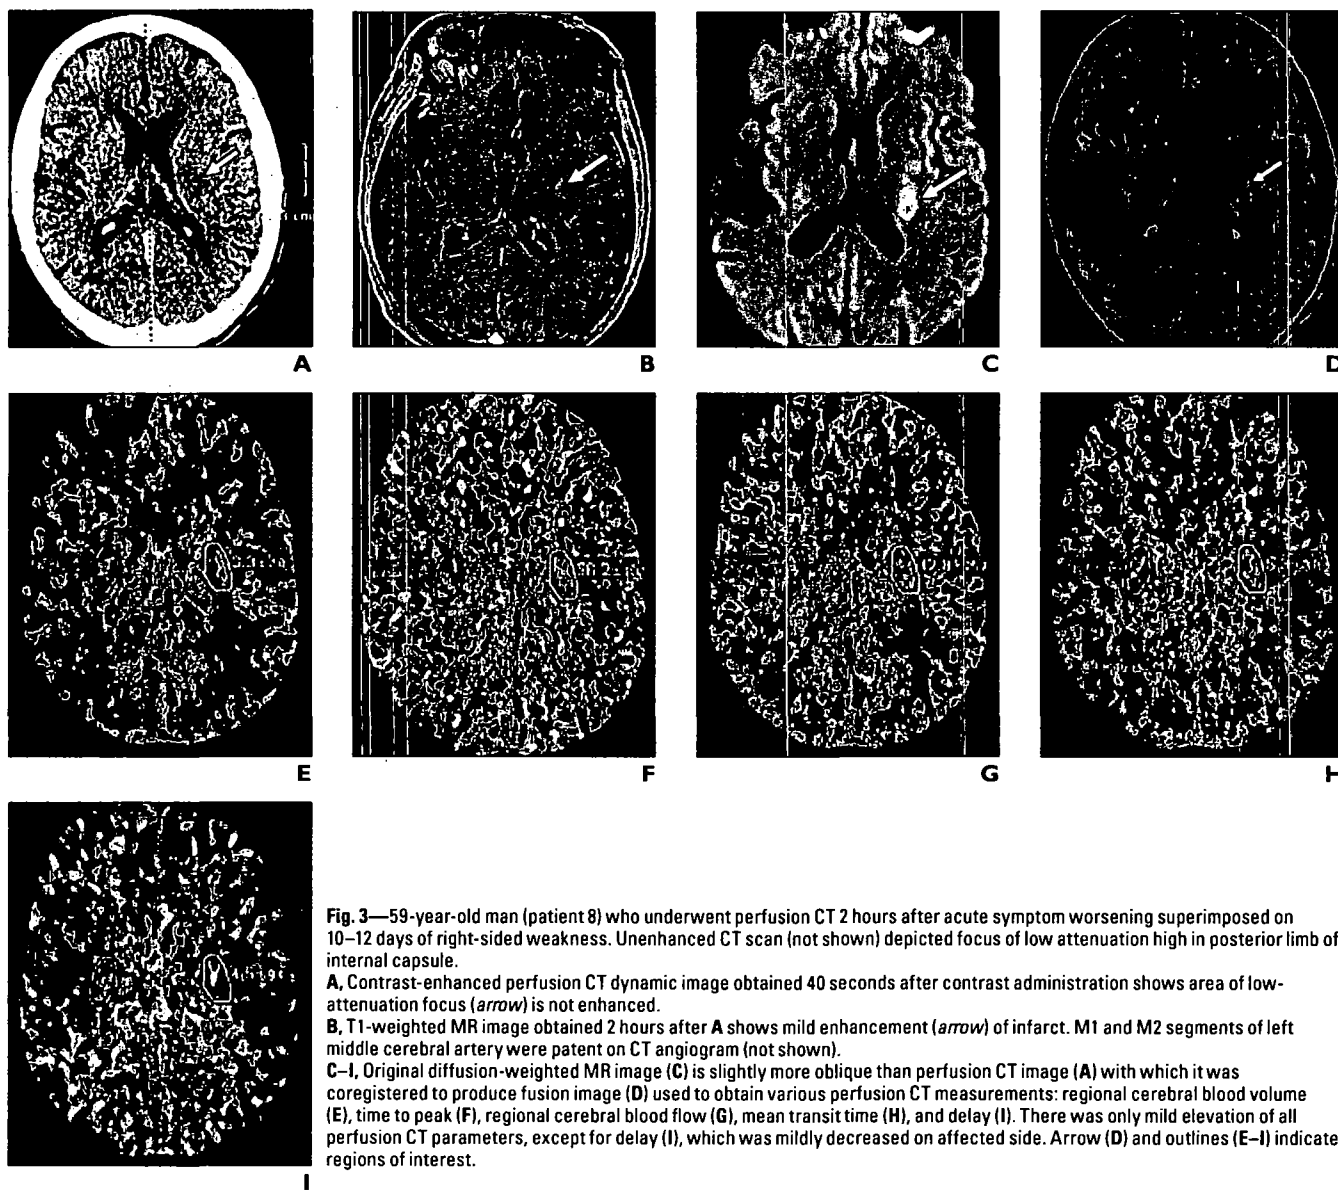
59-year-old man (patient 8) who underwent perfusion CT 2 hours after acute symptom worsening superimposed on 10–12 days of right-sided weakness. Unenhanced CT scan (not shown) depicted focus of low attenuation high in posterior limb of internal capsule.
